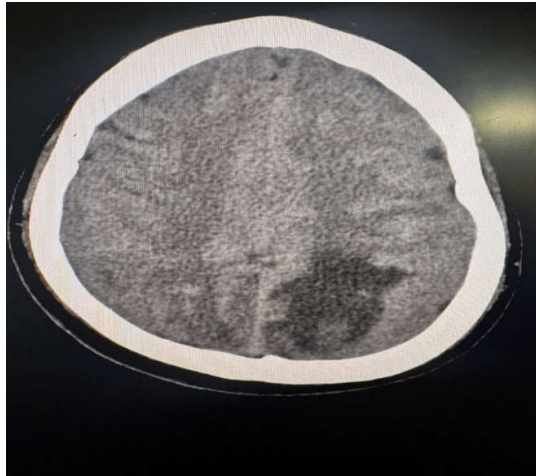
Plain and Contrast CT Brain Showing Bilateral fronto-Parietal Hypodensities Suggestive of Posterior Reversible Encephalopathy Syndrome (PRES) in Eclampsia
